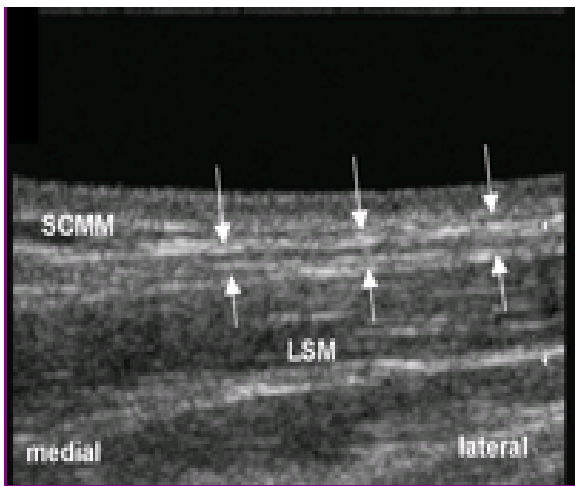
Shows Ultrasonography of the accessory nerve, it appears like tubular structure. The arrows show the nerve course. SCMM - Sternocleidomastoid muscle. LSM- Levator scapulae muscle.
